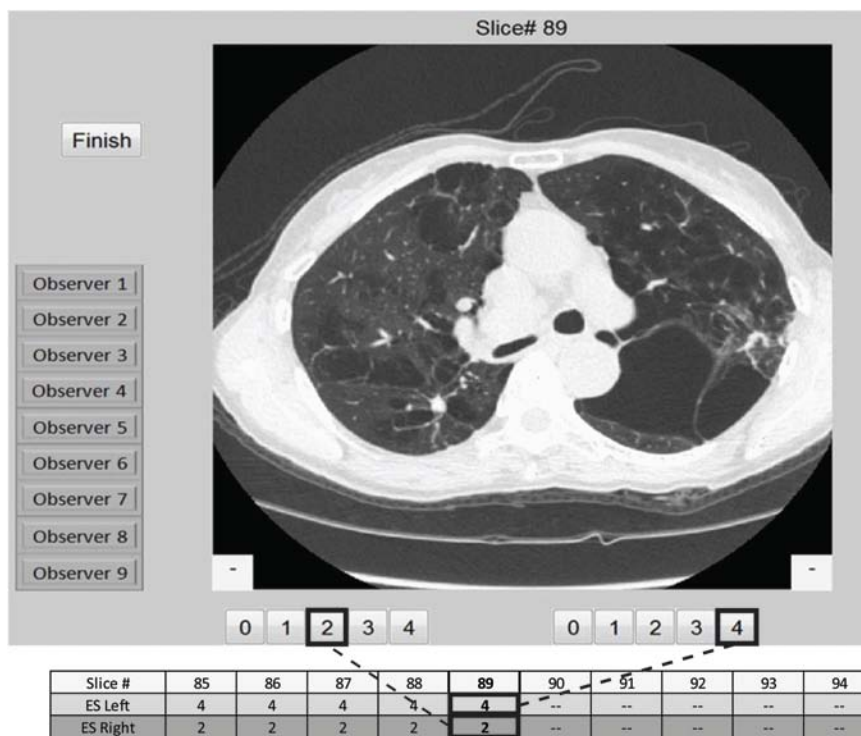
CT emphysema scoring Graphic User Interface.
